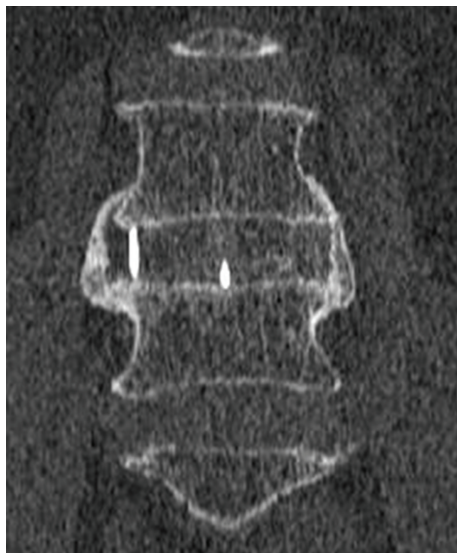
CT image demonstrating fusion.
